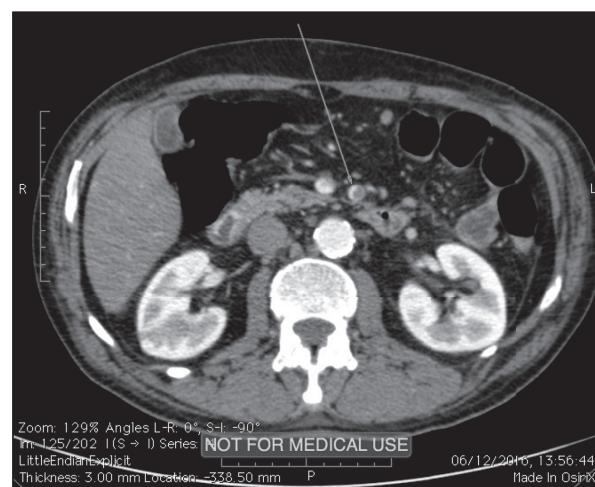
Computed tomography scan with contrast enhanced substance. The arrow indicates the homogenous superior mesenteric artery.
